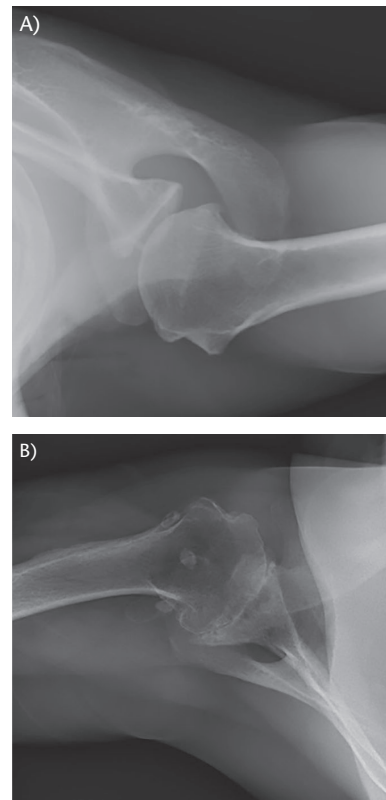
(A) Type A1 glenoid on an axillary lateral radiograph of a left shoulder, characterized by a well-centred humeral head with mild, symmetric glenoid erosion in the absence of glenohumeral subluxation. (B) Type A2 glenoid on an axillary lateral radiograph of a right shoulder, characterized by deeper, symmetric glenoid erosion in which a line connecting the anterior and posterior glenoid rims would transect the humeral head.
